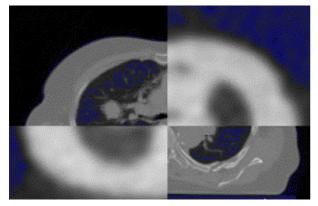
Matching of CT images with PET Scan and Tumour Delineation Facility (after Olver, 2003)
